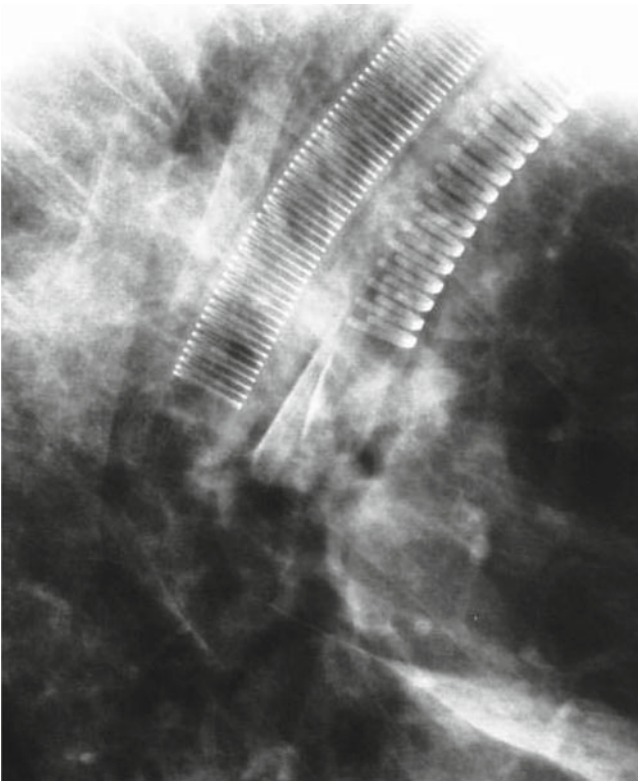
Double stenting of esophagus and trachea. Lateral view on a chest X-ray
